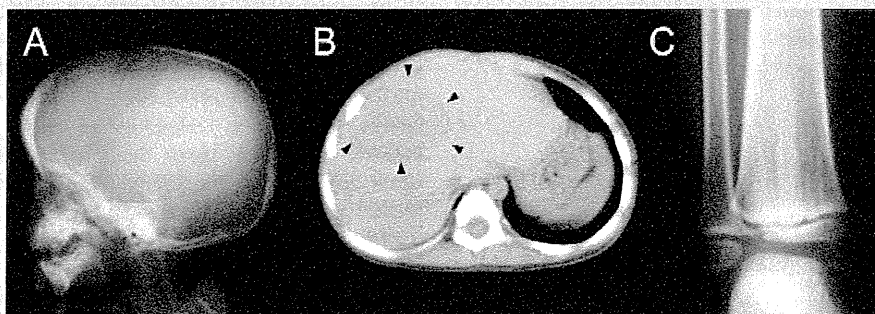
A: Lateral view of cranial X-ray image of the patient at 2 years and 4 months showed increased anteroposterior diameter, mild enlargement of anterior fontanelle and thickening and sclerosis of skull bones. B: Preoperative computed tomography of liver in the patient. Arrowheads indicate hepatoblastoma (approximately 5 cm in diameter). C: Radiograph of right ankle at 6 years showed longitudinal striations on tibia.
